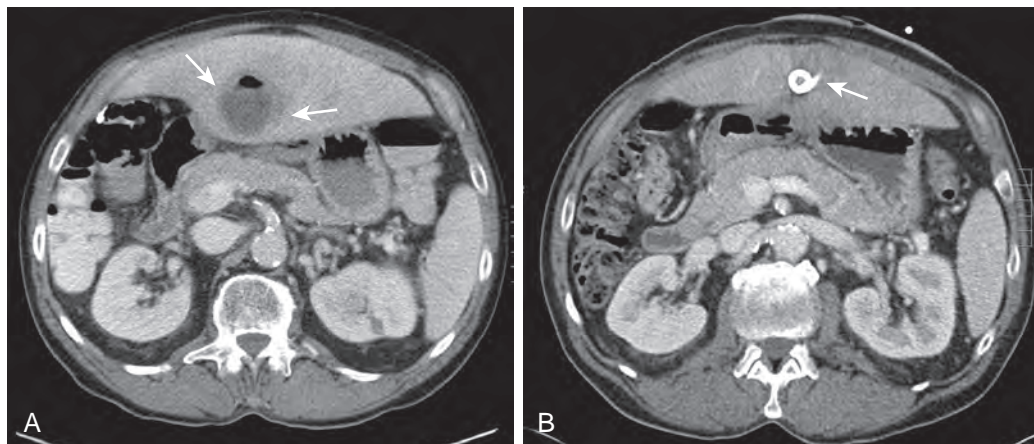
Pyogenic hepatic abscess drained by percutaneous drainage. A. Contrast-enhanced axial CT image shows a peripherally enhancing air-containing abscess in the left hepatic lobe (arrows). B. Contrast-enhanced axial CT image 2 weeks after abscess drainage shows resolution of the left hepatic lobe abscess (arrow).
